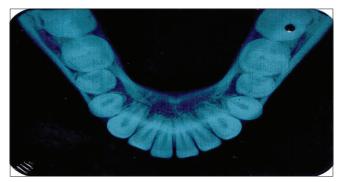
Occlusal radiograph mandibular arch
